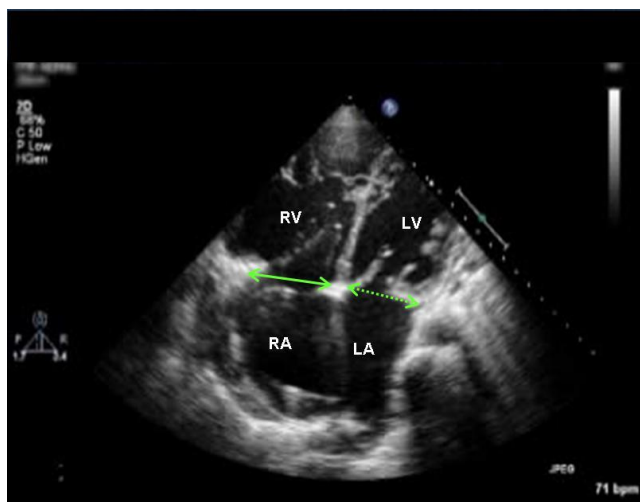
Apical 4-chamber view in a patient with a severely dilated RV. Here, the RV is so dilated the LV appears small, and the apex of the heart is occupied predominantly by the RV rather than being shared between the two ventricles. The inlet dimension of the RV (solid green arrow) is clearly larger than the LV (broken green arrow).
